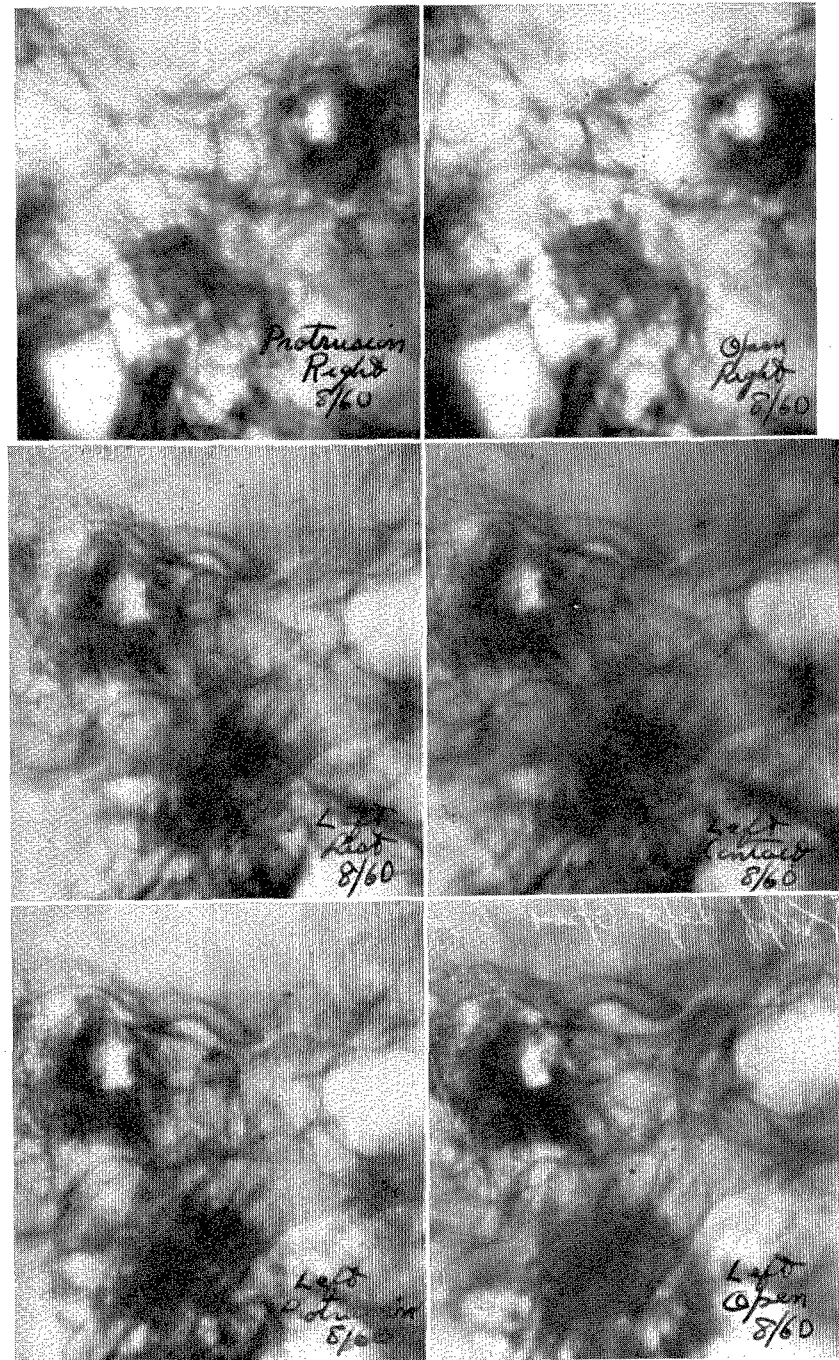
cont'd. For legend see opposite page. Individual positions are written on each separate roentgenogram.
